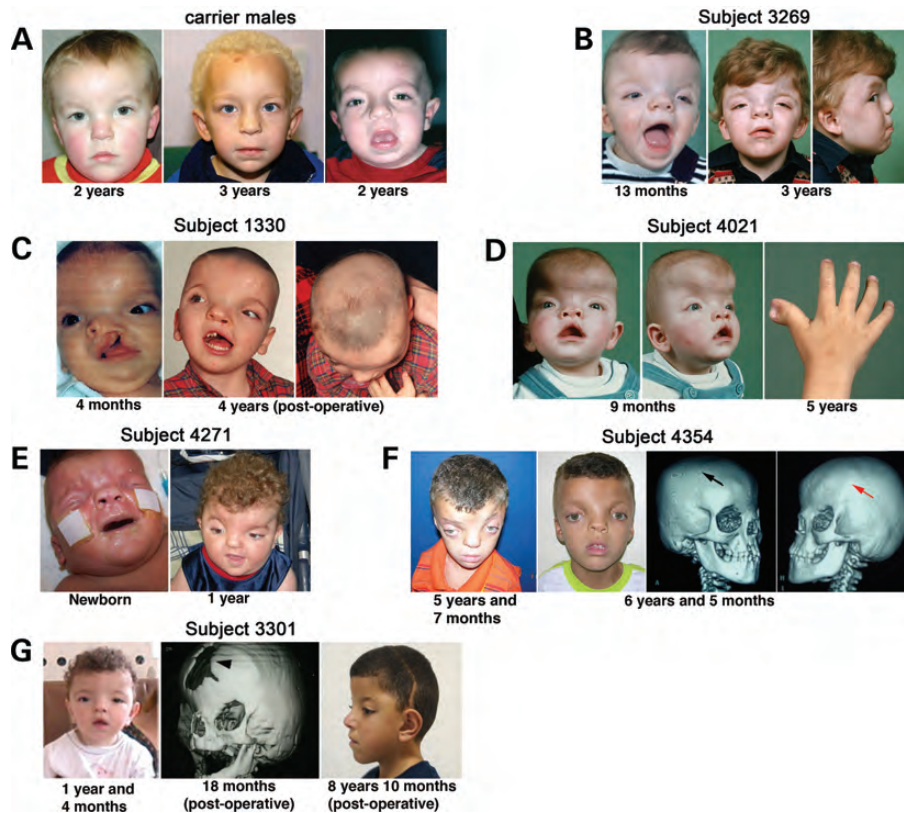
Clinical features of males hemizygous for *EFNB1* mutations (A) and mosaic males analysed in this study (B–G). (A) Previously published males (14,32) with *EFNB1* mutations. The individuals shown are the offspring of females carrying *EFNB1* mutations, indicating that all these males are fully hemizygous; this was confirmed by restriction digest and/or sequencing of DNA isolated from peripheral blood. Note mild facial features of these individuals, who exhibit hypertelorism, but not craniosynostosis. (B–G) Males diagnosed with CFNS (pre-operative images unless stated). Common features include coronal craniosynostosis [three-dimensional computed tomographic skull reconstructions in Subject 4354 (F) shows a patent right coronal suture (black arrow), but the left coronal suture is absent (red arrow) and instead there is a bony ridge; Subject 3301 (G) has a large ossification defect in the position of the metopic suture (arrowhead) and coronal craniosynostosis], craniofacial asymmetry [shown most clearly in the top view in (C)], hypertelorism, downsloping palpebral fissures and broad nasal roots with bifid nasal tips. Wiry hair is also present in most cases. Subject 1330 also presented with unilateral cleft lip (C) and Subject 4021 with duplex thumbs (D).
